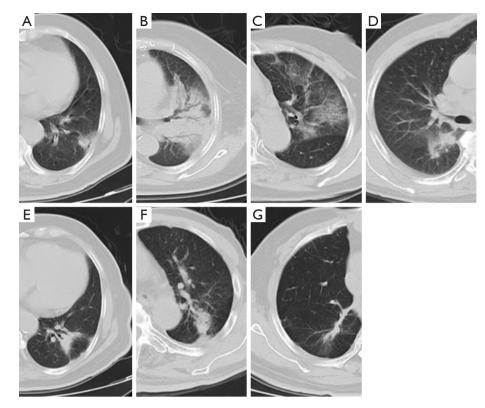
CT features of acute and late RILI. (A) Patchy GGO; (B) diffuse consolidation; (C) diffuse ground glass opacity; (D) patchy consolidation and GGO; (E) modified conventional pattern; (F) mass like pattern; (G) scar-like pattern. RILI, radiation-induced lung injury; GGO, ground glass opacity.
